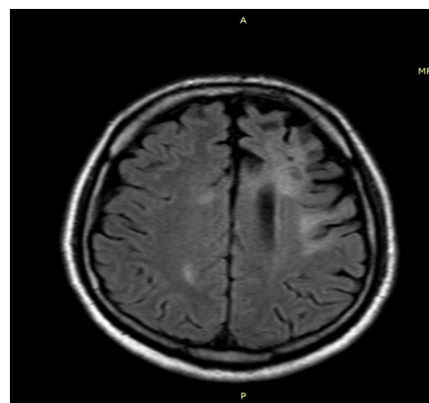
MRI (7 February 2013).
